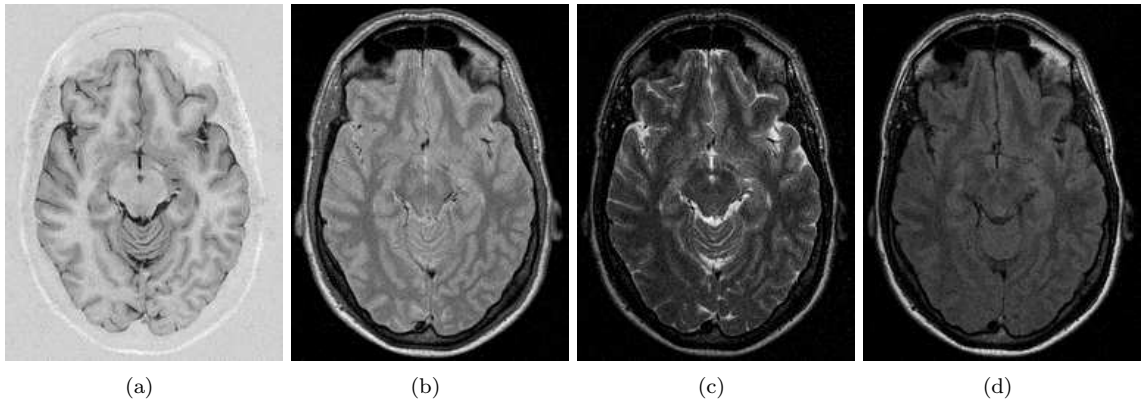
Examples of the MR data used: IRTSE (a), VE(PD) (b), VE (T2) (c) and FLAIR (d).
